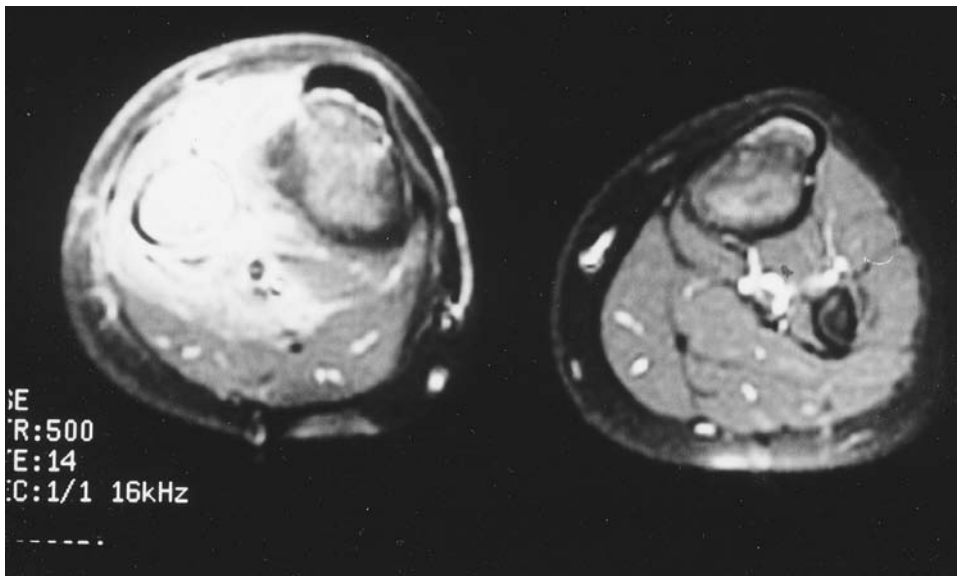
Magnetic resonance imaging of osteomyelitis of the proximal right fibula.
